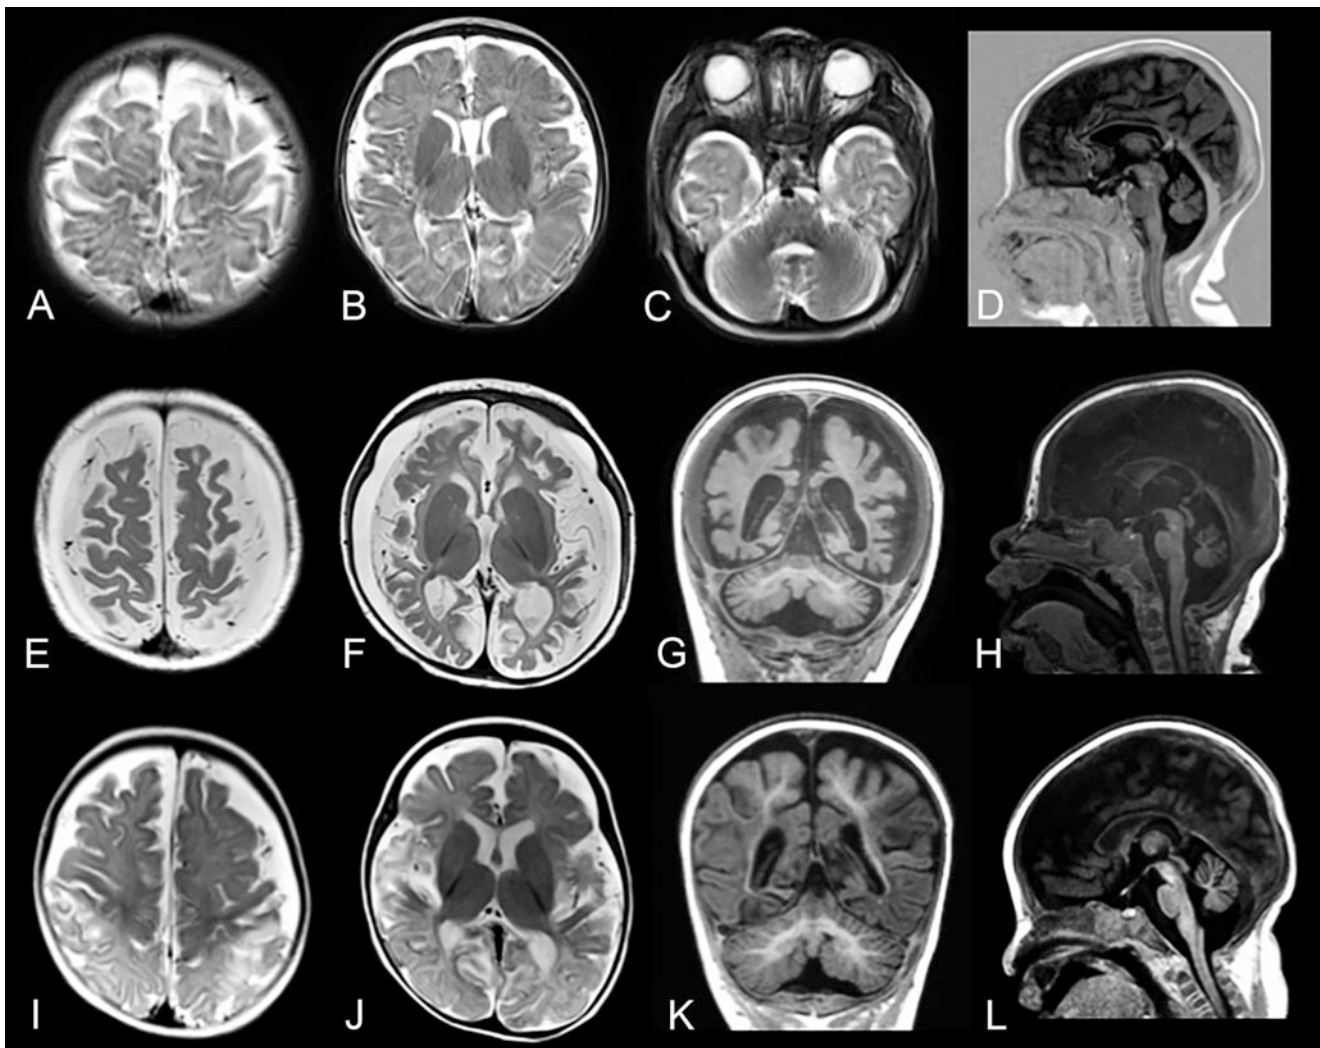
Brain MRI of patients A and B. Axial T2-weighted (a–c, e, f, i, j), sagittal (d, h, l), and coronar (g, k) T1-weighted MR images of patient 1 aged 3 months (a–d) and 6 months (e–f) and patient 2 (aged 3 months, i–l). Note the bilateral subcortical T2 signal elevation of the central region in patient 1 (a) and of the central and parietooccipital cortex and white matter in patient 2 (i, j). Between the first and second MRI, severe supratentorial atrophy develops in patient 1 (a, b vs e–g).
